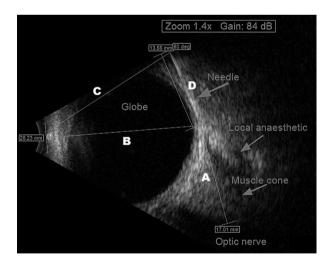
Ultrasound-guided periconal block: 1, needle shaft; 2, local anaesthetic; 3, muscle cone; 4, optic nerve; 5, globe.
